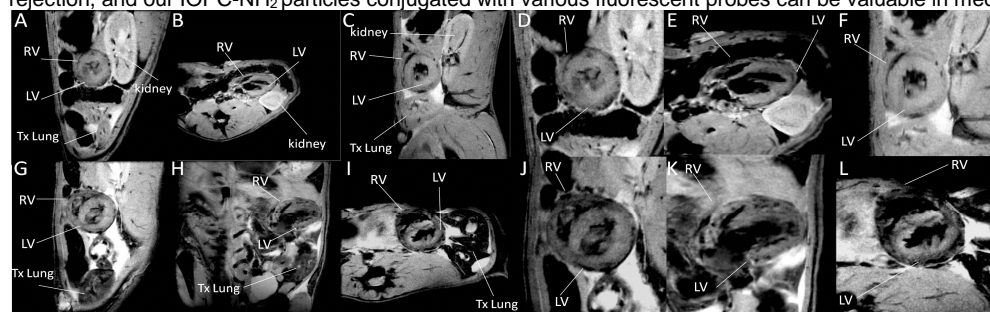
In vivo* T₂^{*} MRI of heterotopic transplanted allograft heart and lung after administration of IOPC-NH₂-labeled T-cells (top panels, A-F) or IOPC-NH₂-labeled macrophage (lower panels, G-L) on POD 4. (A, D, G, J) short-axis view on POD 5; (B, E, H, K) long-axis view on POD 5; (C, F, I, L) short-axis view on POD 6. The right panels (D-F; J-L) are enlarged partial filed-of-view from the same images on the left (A-C, G-I). LV: left ventricle of transplanted heart; RV: right ventricle of transplanted heart; TxLung: transplanted lung. The *In vivo* T₂^{*} MRI is acquired with 156-micrometer in-plane resolution at 7-Tesla.
